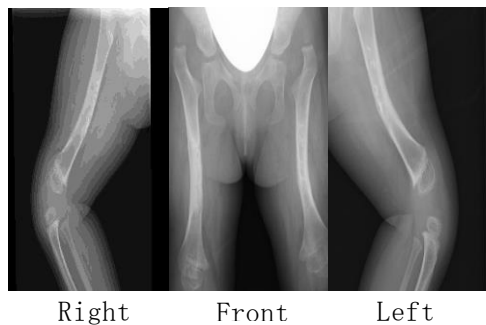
X-ray image of Knee joint after removal of the metal plate (876 days after birth)
